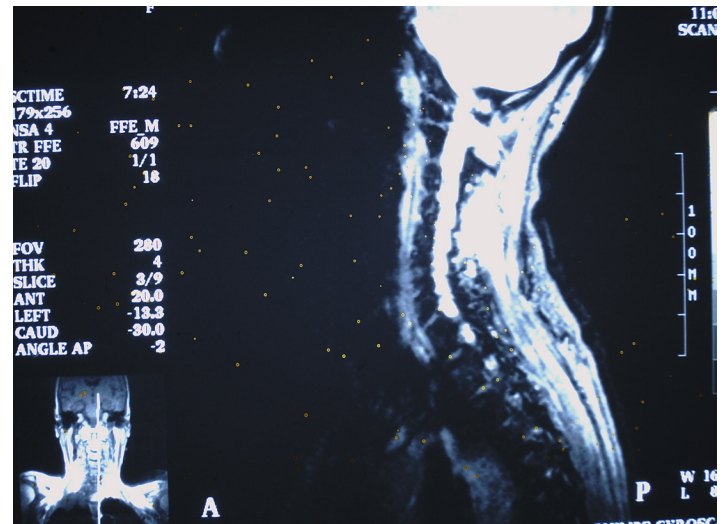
CT of neck and shoulders showing a right-sided apical lung tumor with cervical metastasis.
